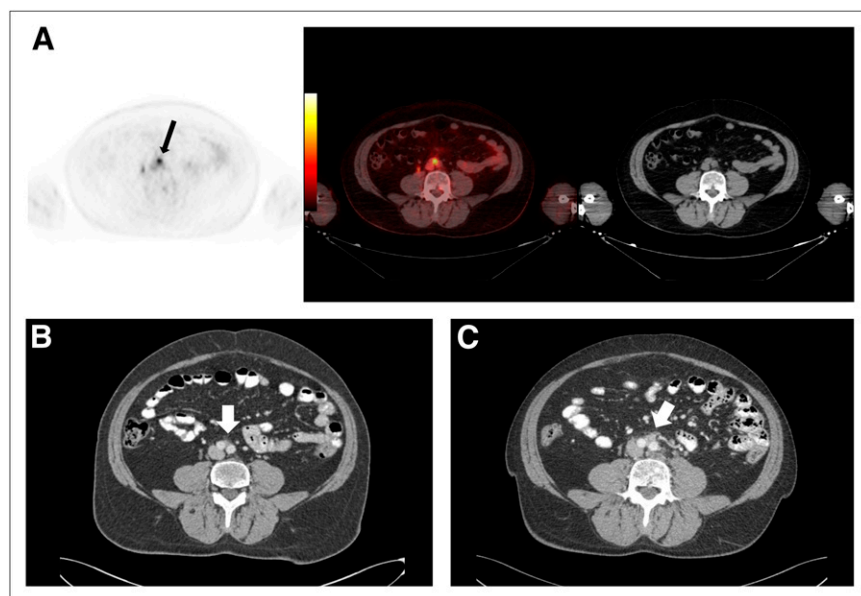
(A and B) Focal ^{18}F -DCFBC PET uptake at aortic bifurcation (arrow, A) with correlative small LN seen on concurrent contrast-enhanced CT (arrow, B), not considered to be nodal metastasis by CT but positive by PET. (C) Retrospective review of prior contrast-enhanced CT scan obtained 1 y previously demonstrates LN in this region (arrow).
